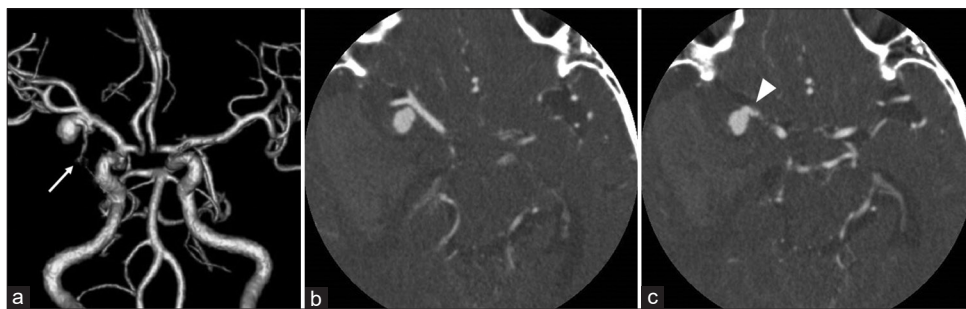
(a) Three-dimensional computed tomography angiography (3DCTA) showing an aneurysmal rounded mass in contact with the middle cerebral artery bifurcation. (b and c) The aneurysmal rounded mass was separated from the middle cerebral artery on axial source image of CTA and a tortuous vessel arising from the aneurysmal mass (arrow).
